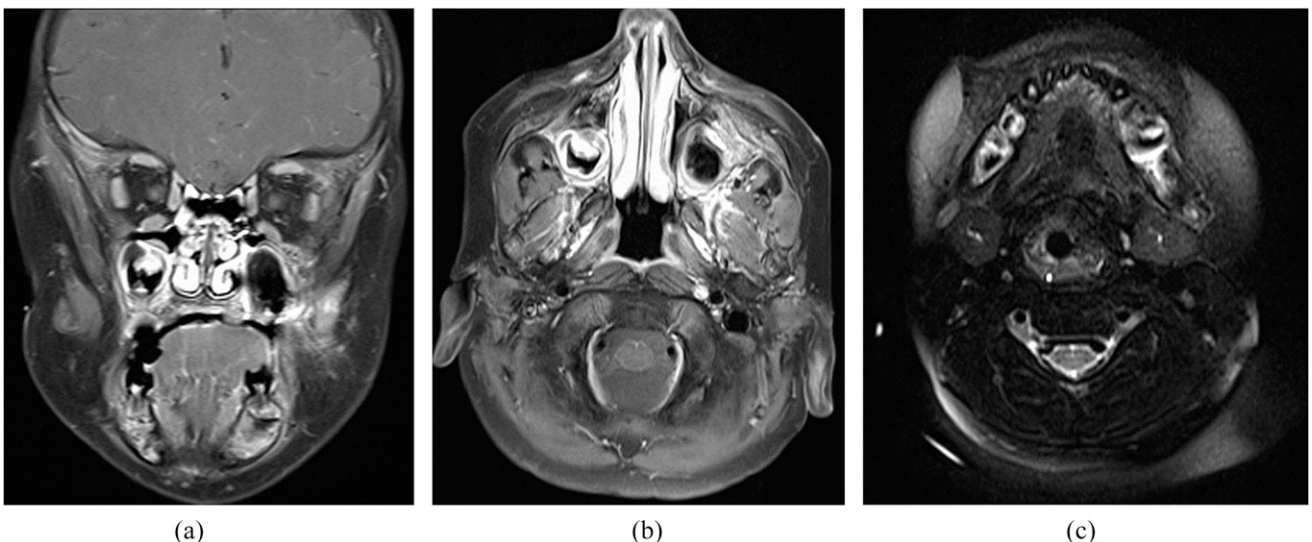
(a–c) MRI after 3 months of therapy. (a, b) Coronal and axial post-contrast axial T₁ fat saturation showing a significant decrease in the size of the mandibular and maxillary lesions. (c) Mandibular lesions and neck lymph nodes have significantly decreased.
